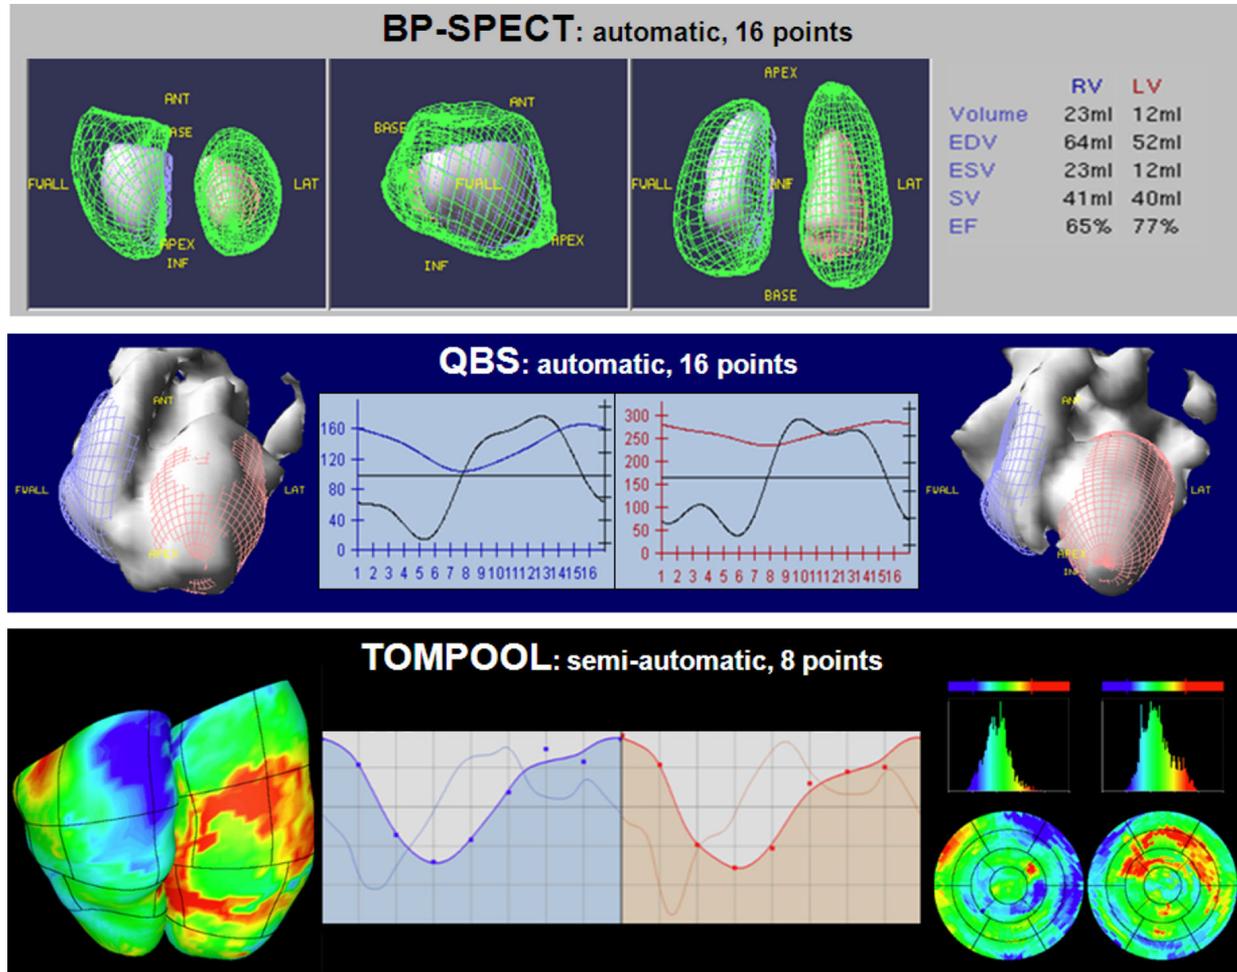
Modeling the shape of the right ventricle by T-ERNV. Representation of the outlines and time-activity curves according to TOMPOOL, QBS, and BP-SPECT. Right ventricle (*blue*) and left ventricle (*red*).
